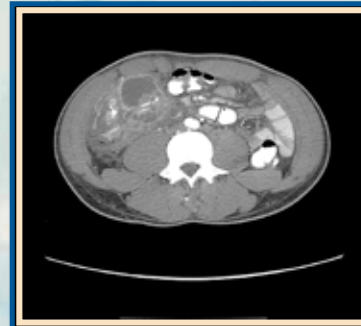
Abdominal CT scan, axial view showing loculated, septated collection abutting the ileocecal area.
